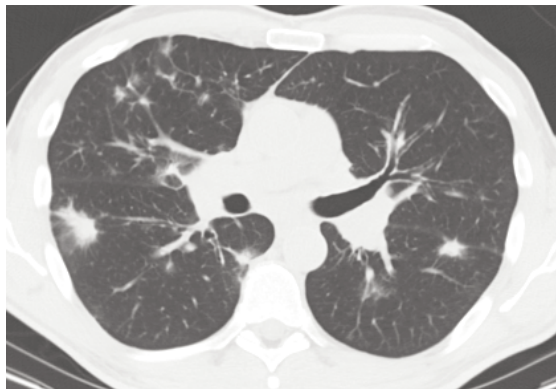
Chest CT of a 55-year-old man with IgG4-related lung disease consisting of multiple solid irregularly margined nodules bilaterally. Transbronchial biopsy demonstrated interstitial and perivascular lymphoplasmacytic infiltrate with 30 IgG4⁺ plasma cells per high power field and 90% IgG4⁺/IgG⁺ plasma cell ratio. PET scan demonstrated FDG uptake in multiple organs including the lungs, mediastinal lymph nodes, salivary glands, lacrimal glands, and the pancreas.
